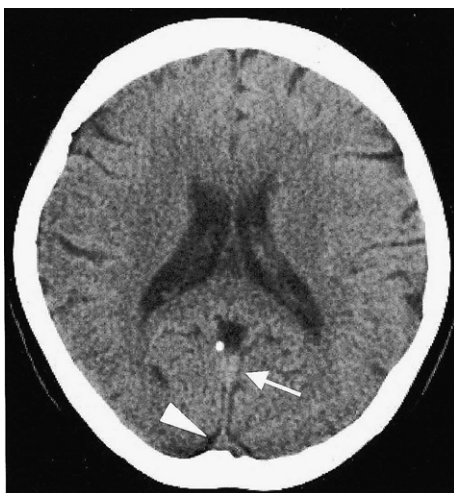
CT scan from the first examination, revealing no apparent abnormal findings. However, the densities of the superior sagittal sinus (arrowhead) and the straight sinus (arrow) are slightly increased.
